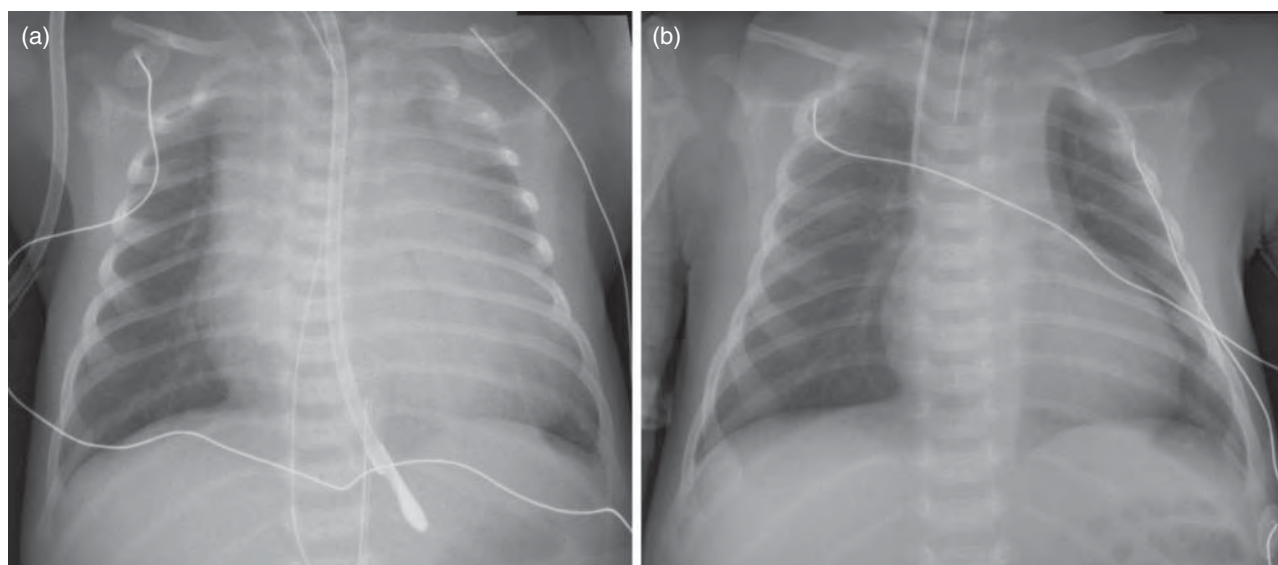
Chest radiograph in neonate with large vein of Galen aneurysmal malformation (VGAM). (a) Significant cardiomegaly is present at diagnosis on day of life 1. (b) Improvement in cardiac size after three sessions of embolization therapy with complete occlusion of the VGAM (endotracheal tube placed for interventional procedure), age 3 weeks.
